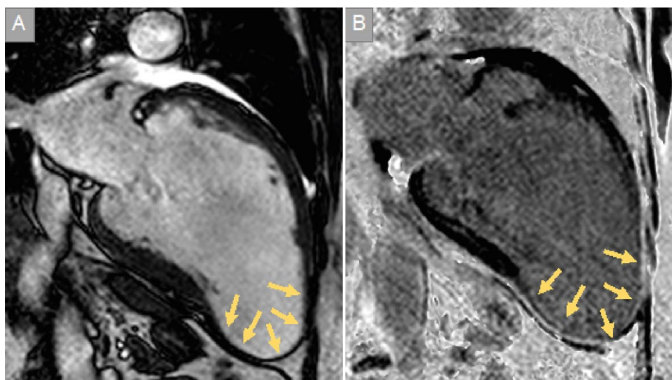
Wide neck aneurysm at the apex of the left ventricle. Two-chamber tomographic sections obtained in cine-magnetic resonance imaging in diastole showing parietal thinning and cavity enlargement in the apical region (A). Delayed gadolinium enhancement sequence showing an extensive hypersignal region compatible with transmural fibrosis in the aneurysmal area (C).
